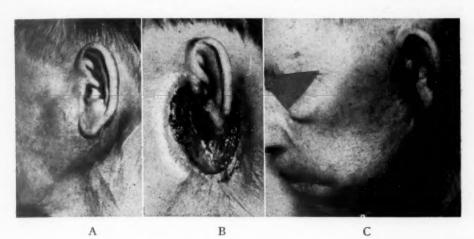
(A) Carcinoma of the parotid gland. One year prior to admission, a mass which had been diagnosed "mixed tumor of the parotid" was surgically excised and the area treated with x-ray. The recurrent mass was hard and fixed and it measured 60 by 63 mm. (B) Lesion after chemosurgical excision. Because of the definitely infiltrative character of the neoplasm (Fig. 4B) a diagnosis of carcinoma was made. The neoplasm infiltrated around the main branches of the facial nerve so complete paralysis resulted from the chemosurgical removal. The inferior wall of the external auditory canal was also invaded. (C) Healed lesion three months later. The complete facial paralysis is apparent. There has been no recurrence after three years.
